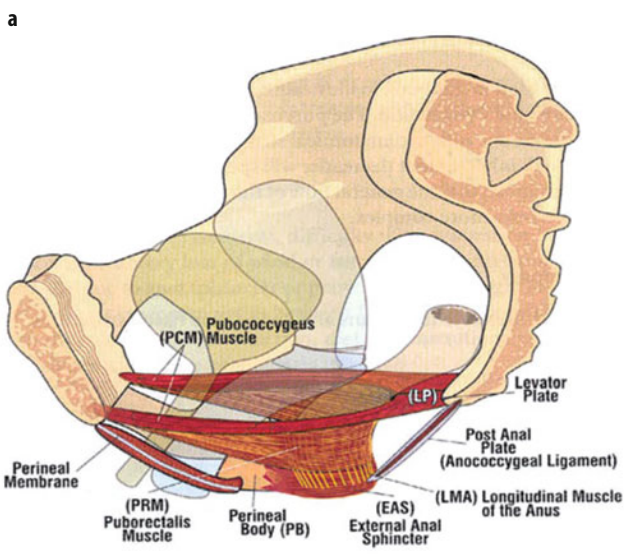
a, b. Passive and active structures of the pelvic floor. a Pelvis with organs and muscles (muscles are shaded with striations). b The corresponding sagittal T2-weighted turbo spin-echo magnetic resonance images of pelvic organs, pelvic floor muscles, perineal body, and anococcygeal ligaments
